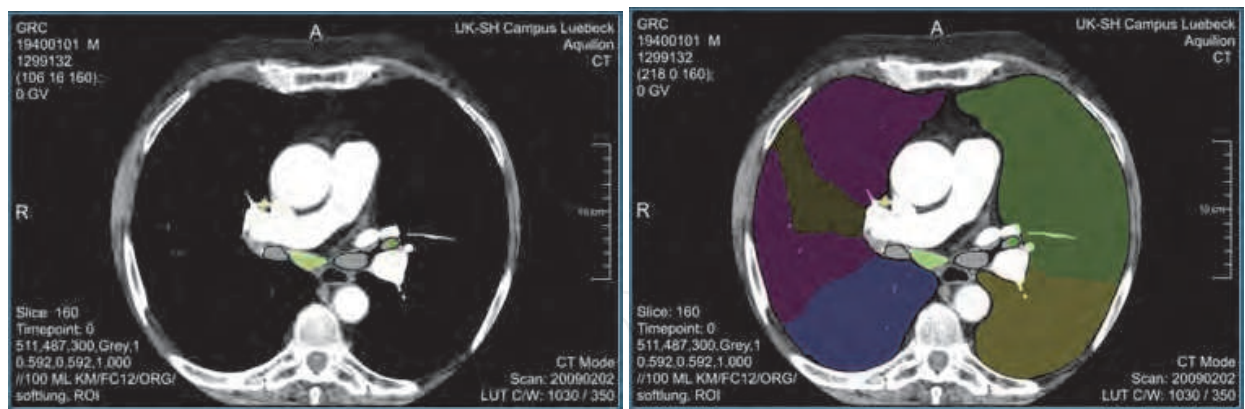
Colour-coding of the central vessels and the bronchial system (left). Axial computed tomographic scan of the thorax with colour-coding of the lung lobes. (right)
